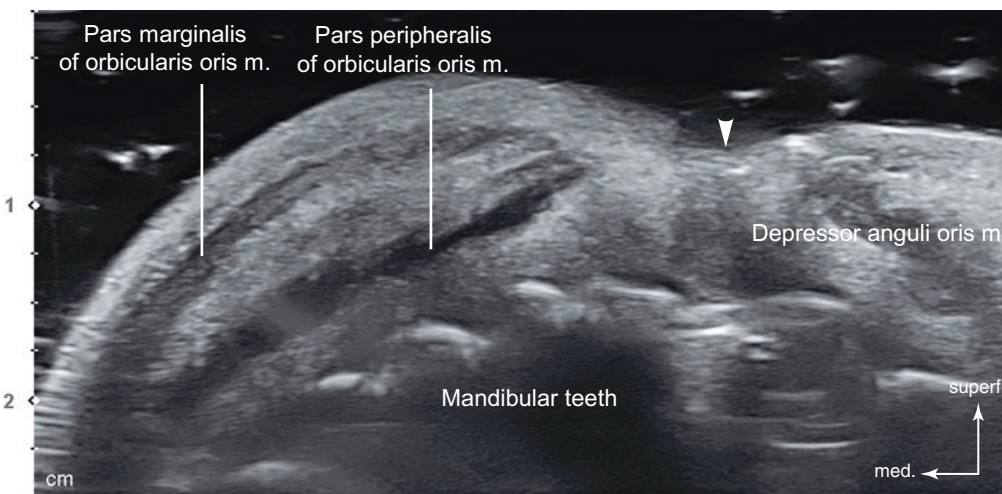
Ultrasonography of the oblique line between Li2 and Li3 (Li2–Li3). B mode (oblique view, 15 MHz by linear transducer) (arrowhead: labiomandibular fold). (Published with kind permission of © Hee-Jin Kim 2020. All Rights Reserved)
